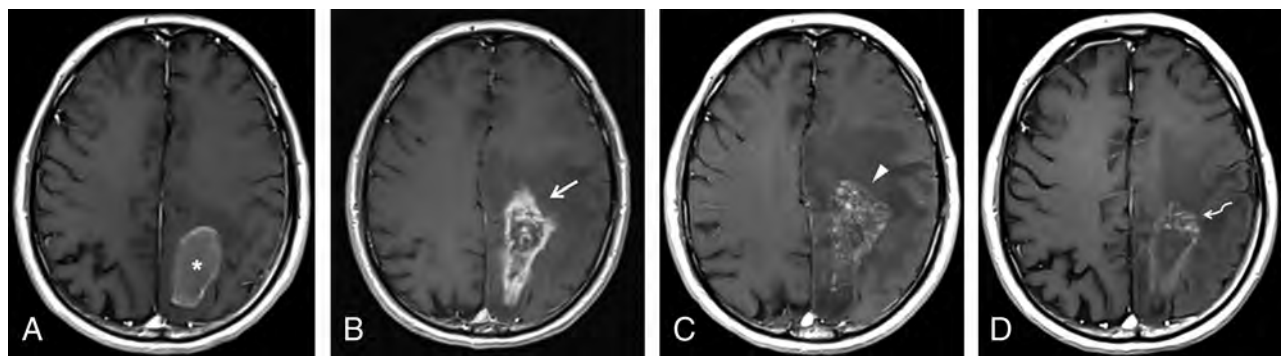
Pseudoprogression in a 56-year-old man who underwent chemoradiation after gross total resection of a GBM in the left parietal lobe. A, Axial contrast-enhanced T1-weighted image obtained 1 week after an operation shows thin ring enhancement in the surgical bed (asterisk), which was considered to represent granulation tissue, related to the operation. The study was not obtained within the first 48 hours due to hemodynamic instability of the patient. B, Soon after completion of radiation therapy, the patient developed marked enhancement in the margins of the surgical cavity (arrow), with effacement of the adjacent sulci. In the following 3 months, he presented with progressive altered mental status and right-side hemiparesis. C, At that time, axial contrast-enhanced T1-weighted imaging showed an increase in mass effect, midline shift, with a slight increase in enhancement extension, which turned to a soap bubble appearance (arrowhead), a pattern typically associated with radiation necrosis. D, The patient improved clinically, and after 4 months, a new image depicted fading of the enhancing lesion (curved arrow) and a marked decrease in mass effect, which is the classic course of pseudoprogression.
